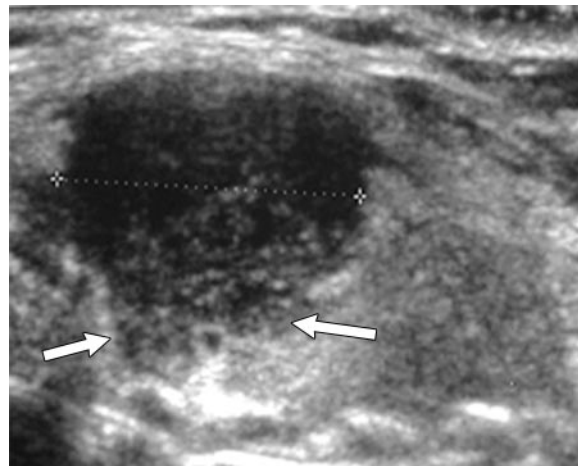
Papillary carcinoma in an 87-year-old man. Transverse sonogram of the thyroid isthmus shows a poorly defined tumor with marked hypochoic and irregular margins (arrows) and without a hypochoic halo.
